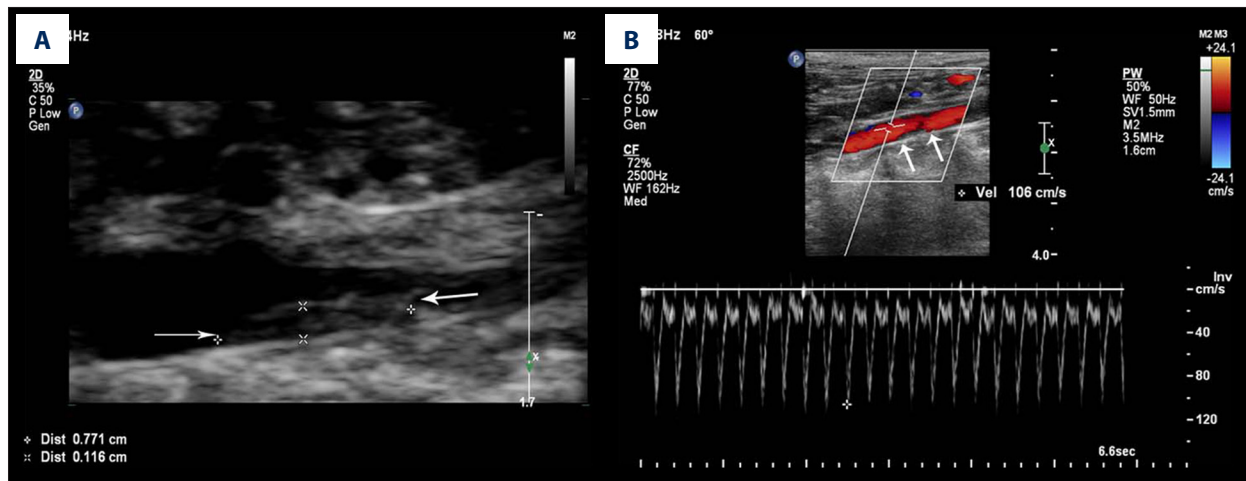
Representative ultrasound images of plaques in rabbits. (A) Two-dimensional imaging of a plaque in a rabbit aorta. The plaque is indicated by arrowheads. (B) Color Doppler flow imaging of the plaque. A filling defect was detected at the position of the atherosclerotic plaque, which is indicated by arrowheads.
